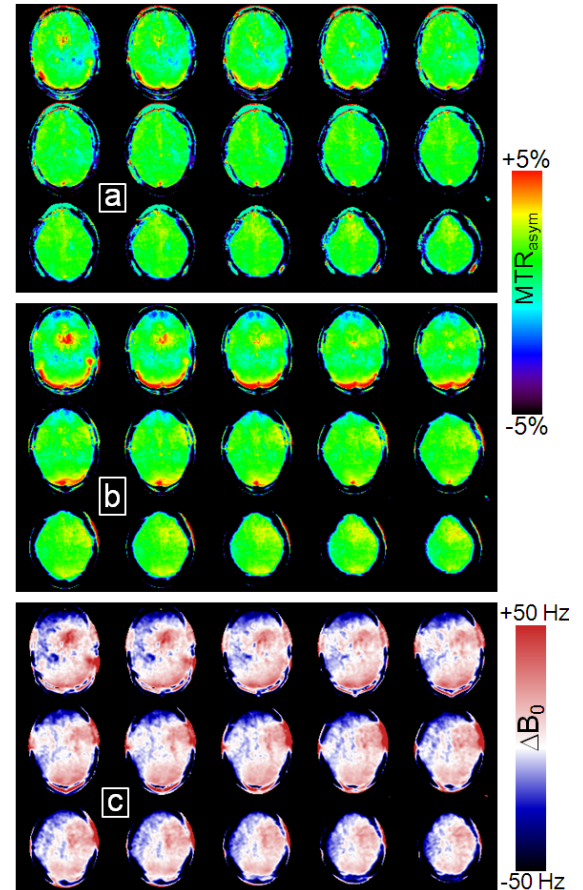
3D APT-MRI with intrinsic homogeneity correction via Dixon B_0 mapping on a healthy volunteer brain. (a) Collection of all 15 slices for the obtained homogeneous MTR_{asym} map with B_0 correction. (b) Asymmetry analysis prior to B_0 correction. (c) Obtained 3-point Dixon B_0 map.
